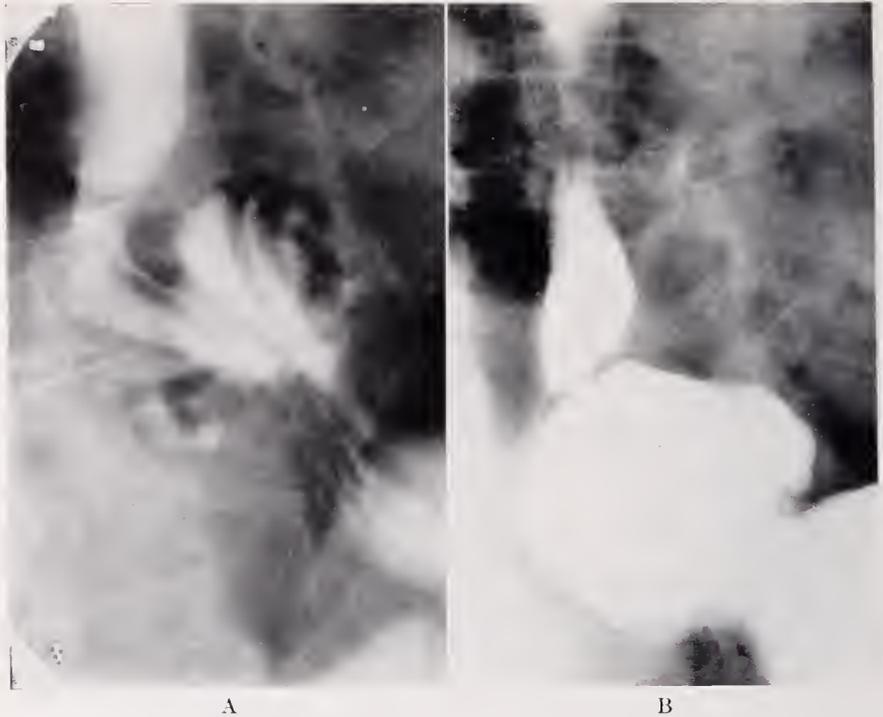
Sixty-five year old woman with dysphagia for large boluses of solid food for many years. Typical sliding or pulsion type of hiatus hernia with the cardia about 6 cm. above the hiatus. Free reflux of barium from the stomach into the hernial sac and into the esophagus was present on roentgen examination. In addition, the esophago-gastric region showed a constant lack of normal distensibility and, when maximally distended, had the typical appearance of a "contraction ring." A. "Double Contrast" view demonstrates rugae extending proximally to site of constriction. B. Demonstrates characteristic features of contraction ring.
